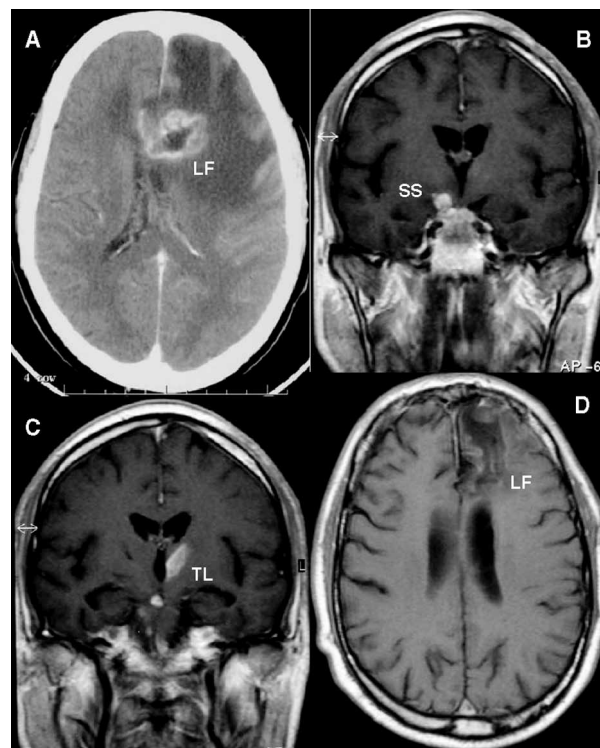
Disease progress monitored by computerized tomography (CT) and magnetic resonance imaging (MRI). A, left frontal lesion (LF) at initial presentation (CT); B, supra-sellar extension (SS) after four months antifungal therapy (MRI); C, left thalamic lesion (TL) after five months' antifungal therapy (MRI); D, residual appearance of left frontal (LF) lesion 12 months after excision of the fungal lesion (MRI).
